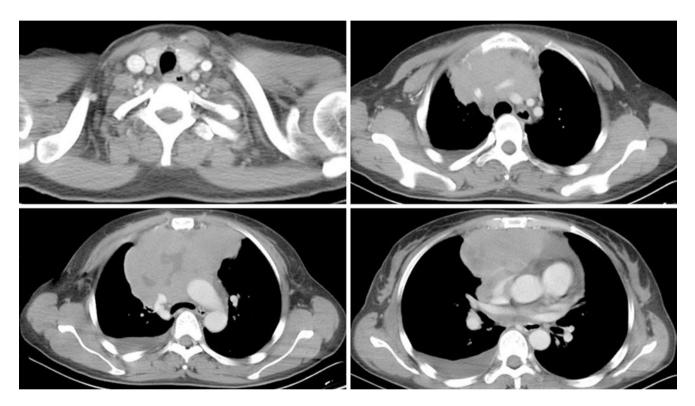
Chest CT images of a 47-year-old woman complained of cough and sputum for 2 weeks
